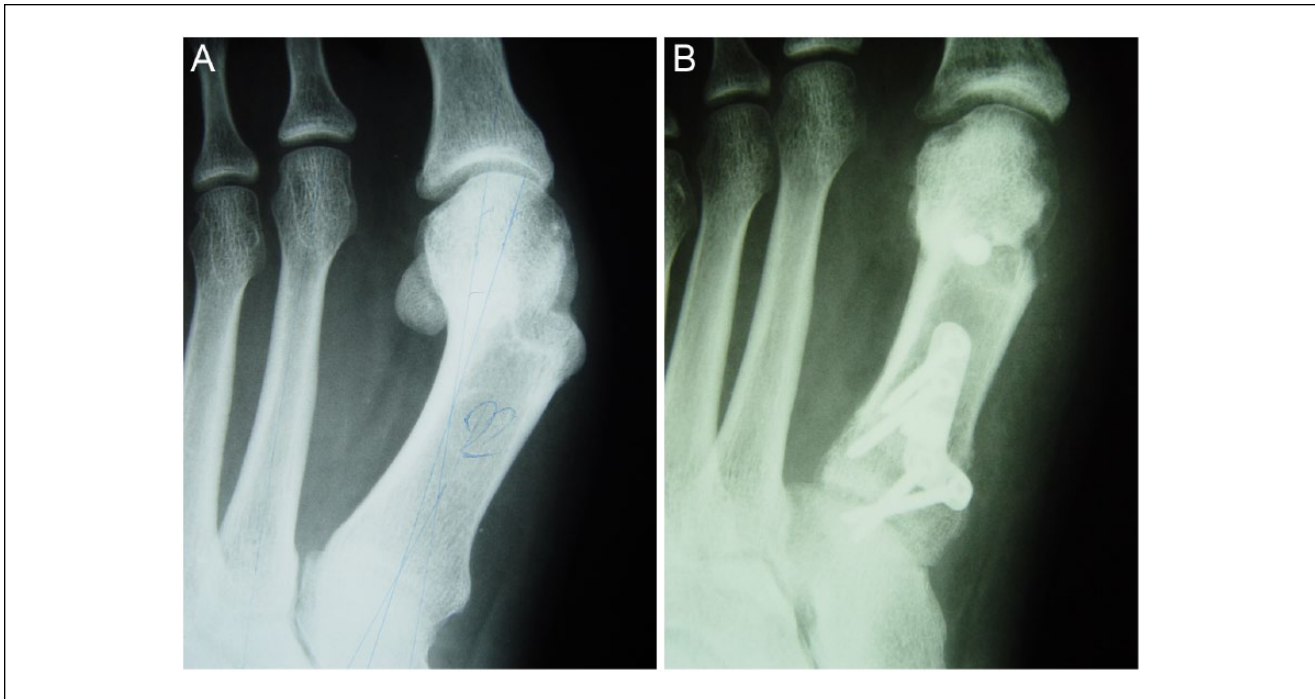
(A) Preoperative AP radiograph showing inadequate correction of a hallux valgus with a distal osteotomy. Note the residual high intermetatarsal angle. (B) Postoperative correction with double osteotomy technique showing correction of intermetatarsal angle and correction of the DMAA.
